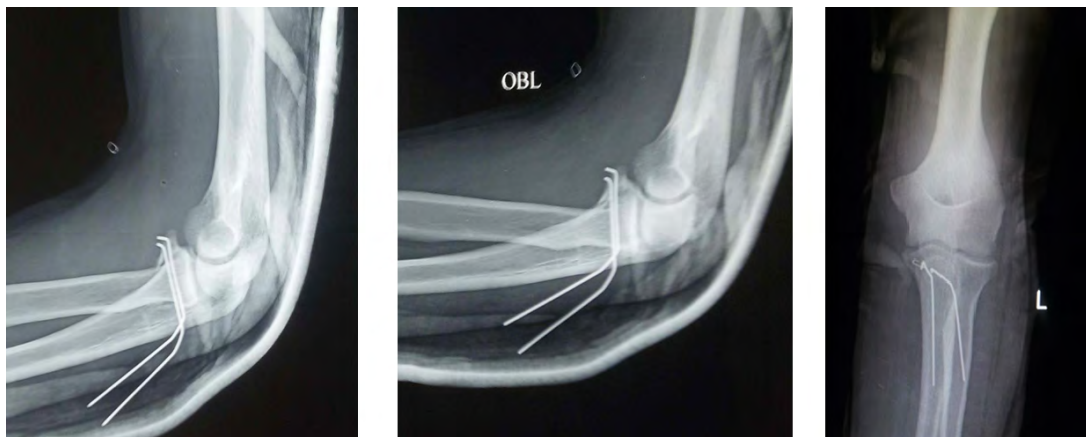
Post OP X-rays showing the coronoid fragment reduced in position by the bend K-wires.
